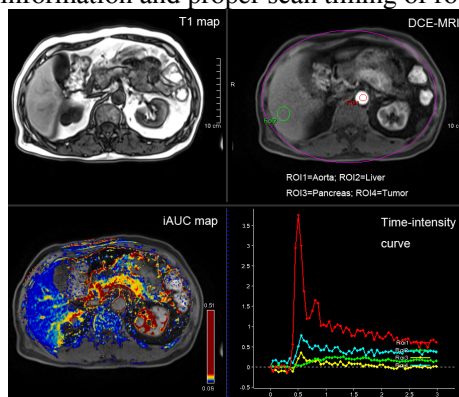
Test-bolus DCE-MRI of the abdomen showed high-quality images and perfusion maps that may enable the analysis of tumor perfusion.
